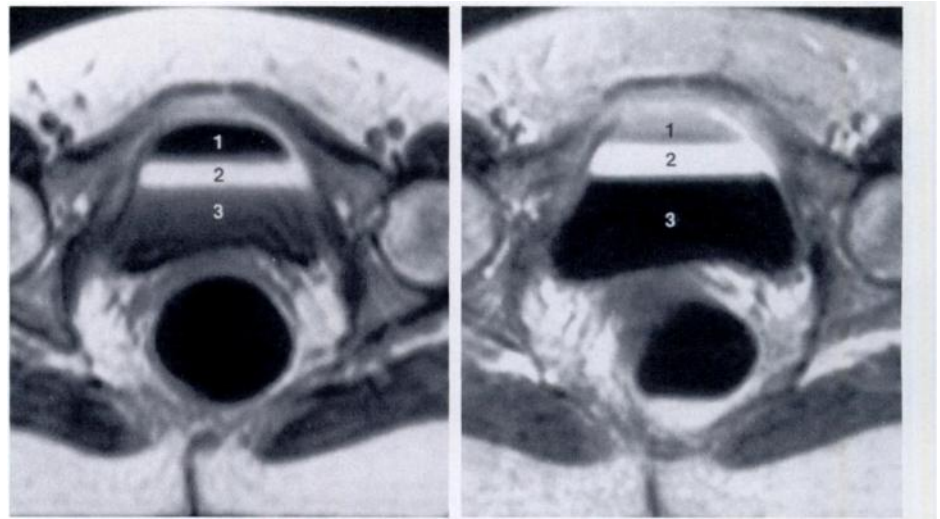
Axial MR images of the pelvis obtained with 600/16 (repetition time [TR] msec/echo time [TE] msec) (a) and 2,000/60 (b) sequences show excretion of Gd-DTPA into the partially filled bladder. Three discrete layers or signal regions (1–3) are identified with each sequence.
